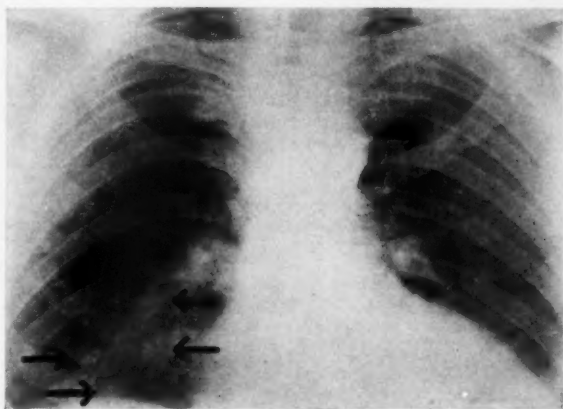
Roentgenogram of the chest (case 4) taken two years before death. There are well circumscribed areas of density in the lower portions of both lung fields.
